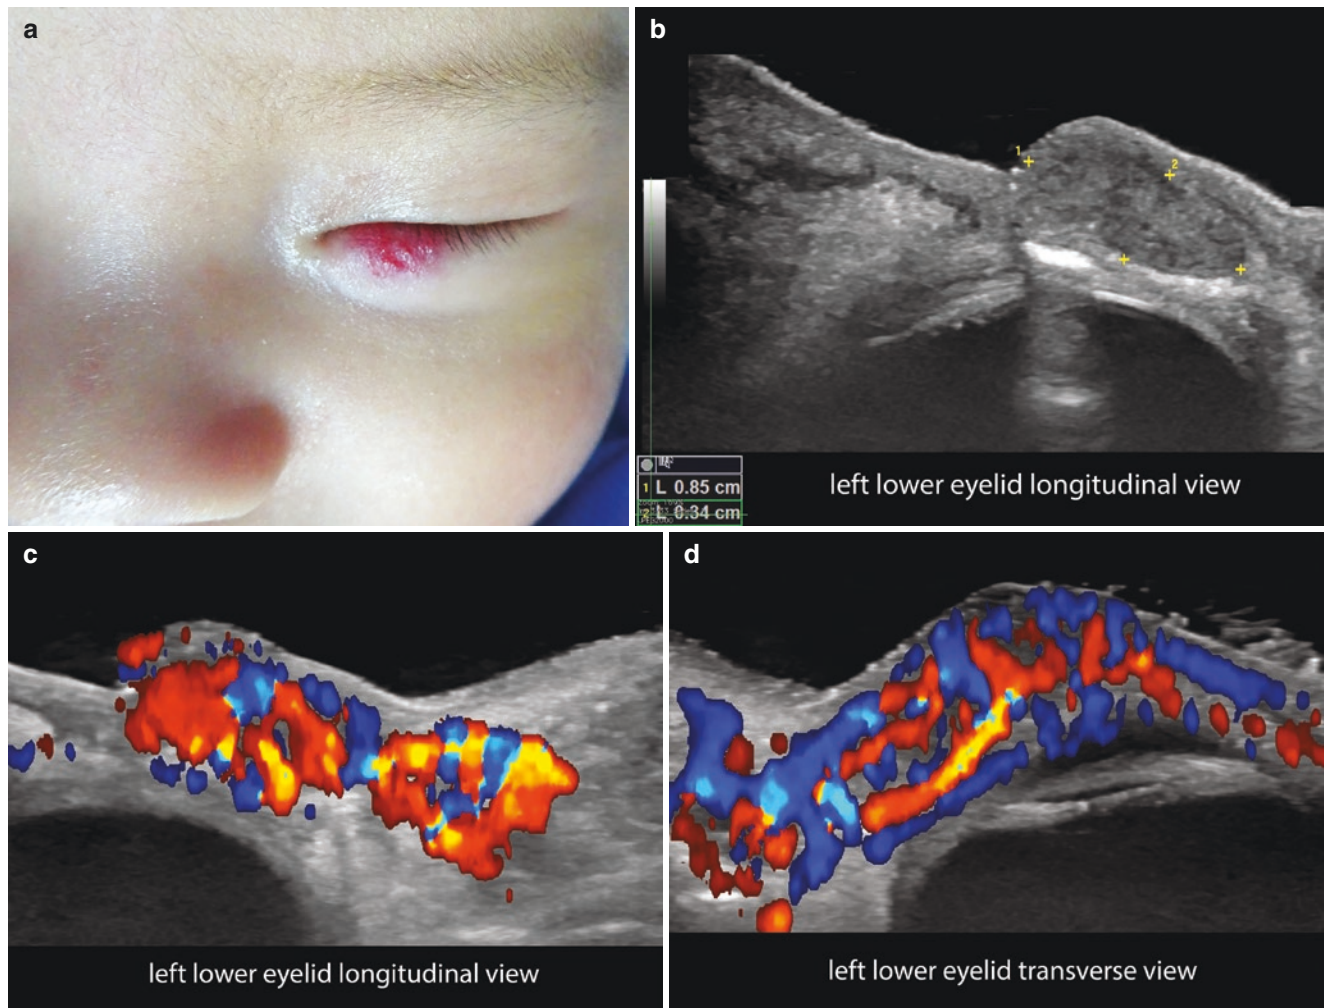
Hemangioma in proliferative phase. (a) Clinical image of the lesion in the lower eyelid. (b–d) Greyscale and color Doppler ultrasound (c, longitudinal view; d, transverse view) demonstrate an ill-defined hypoechoic structure (between markers), 8.5 mm
